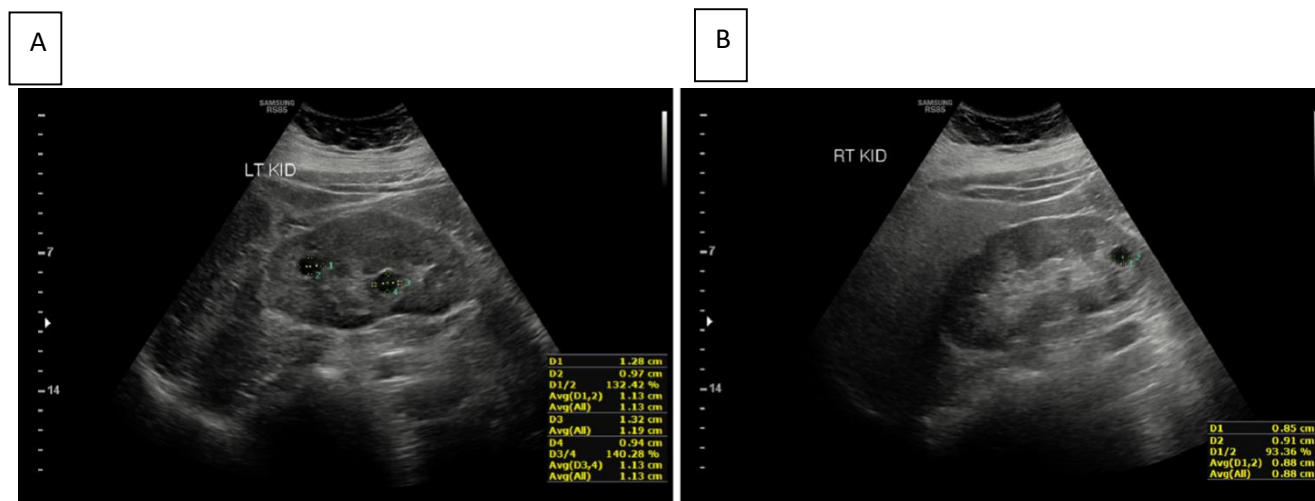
Ultrasound of both the left and right kidney with polycystic measures (cm). A) The left kidney has two dark circles (cysts) the top left cyst is 1.28cm in width (D1) and 0.97cm in height (D2). The central cyst has a width of 1.32cm and the height is 0.94cm. B) The right kidney has one cyst with a width of 0.85cm and the height is 0.91cm.
